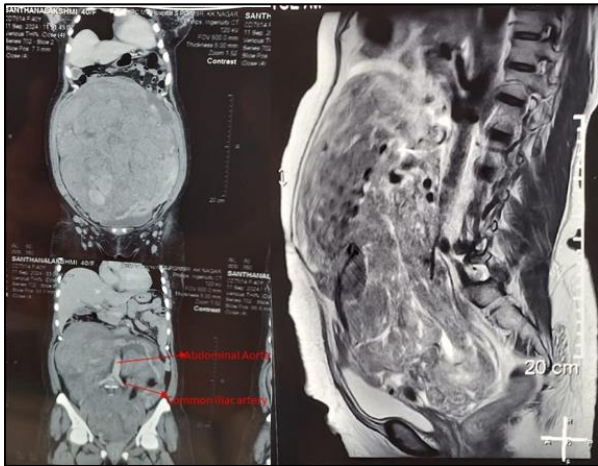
CT/MRI finding of the abdomen showing the extent of the mass.
